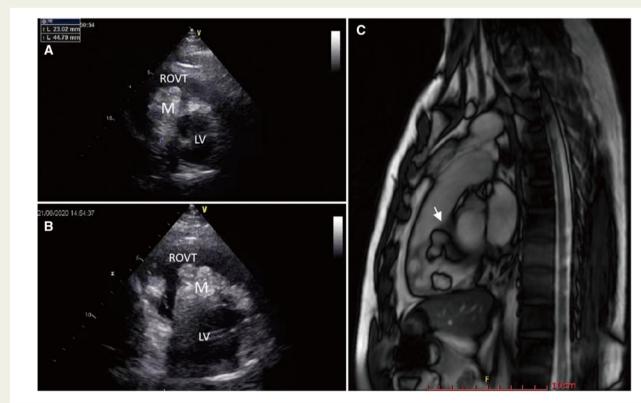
Both echocardiography (A and B) and cardiac magnetic resonance (C, white arrows) showed that the mass partially occluded the right ventricular outflow tract. LV, left ventricular; M, masses; RVOT, right ventricular outflow tract.
